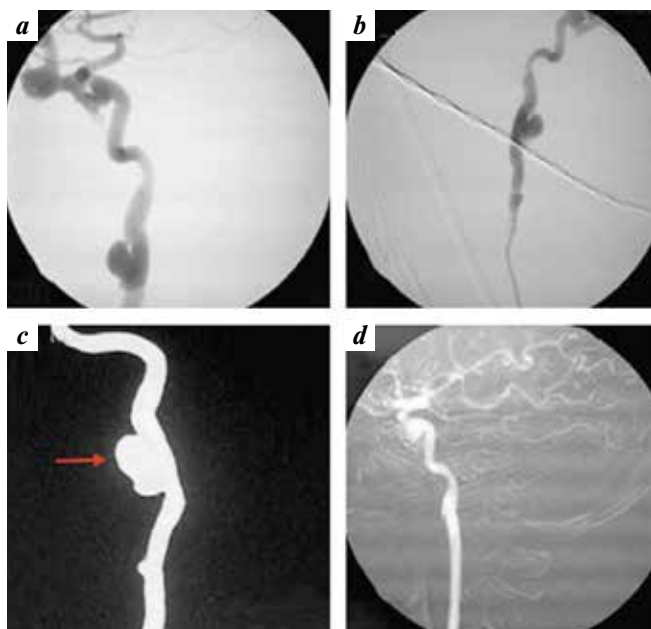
Depicting DSA lateral, oblique lateral views (a, b, c) showing internal carotid artery pseudoaneurysms (arrow – c); depicting CT angiography post stenting, showing complete disappearance of pseudoaneurysms (d)*
